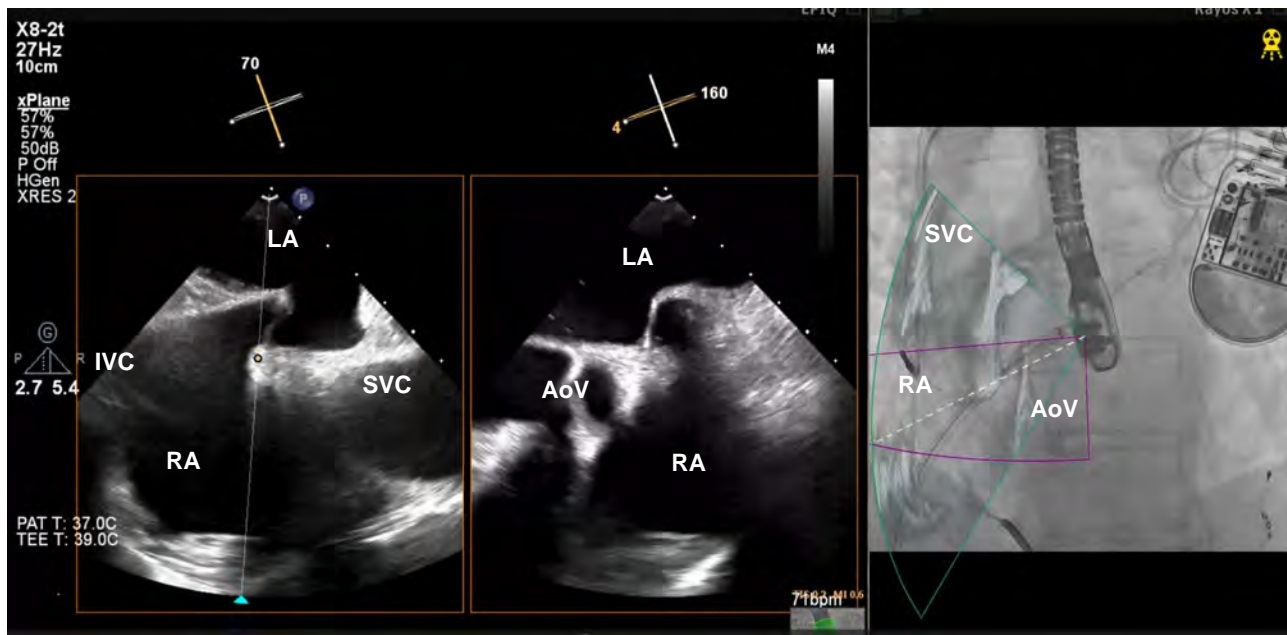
Fusion imaging overlaying three-dimensional transoesophageal echocardiography and fluoroscopy. (A) The panels of the left show the simultaneous biplanar view of the interatrial septum taking as reference plane the bicaval view and short-axis view of the aortic valve as the perpendicular view. (B) This image is overlaid onto the fluoroscopy with the green sector showing the bicaval view. AoV, aortic valve; IVC, inferior vena cava; LA, left atrium; RA, right atrium.
